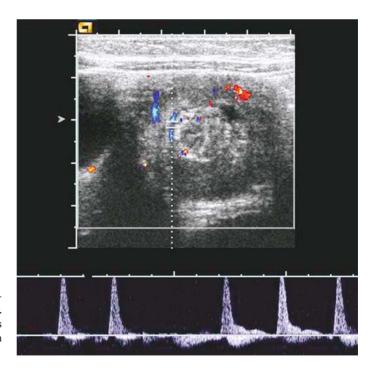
Intussusception. Duplex Doppler sonography. Color Doppler indicates wall vascularity. High resistive index is observed in the vessels within the intussusception. This intussusception could be reduced
